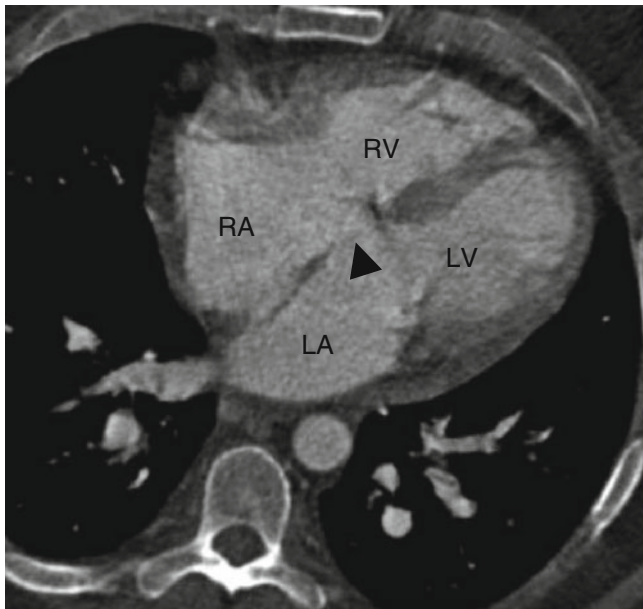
Primum atrial septal defect (ASD). An axial CT shows the ASD (black arrowhead) located between the level of the fossa ovalis and atrioventricular valves. This defect occurs in the lower part of the atrial septum close to the ventricular inlet valves. RA right atrium, RV right ventricle, LA left atrium, LV left ventricle
